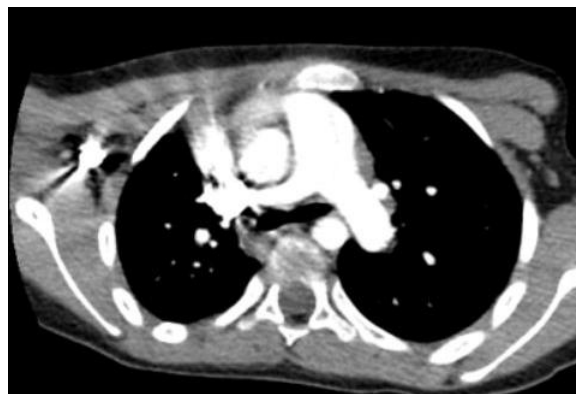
Axial computed tomography section, after injection of contrast medium showing a single right pulmonary vein that drains into the right atrium
